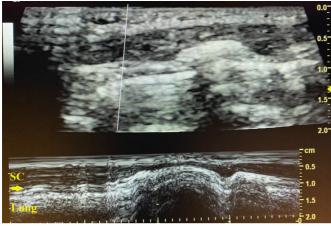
Lung sliding and a shimmering appearance of the pleura. Lung sliding refers to a to-and-fro movement of the visceral pleura in contact with the parietal pleura due to shimmering/glimmering (or twinkling) of the pleural line on 2-Dimensional ultrasound.
